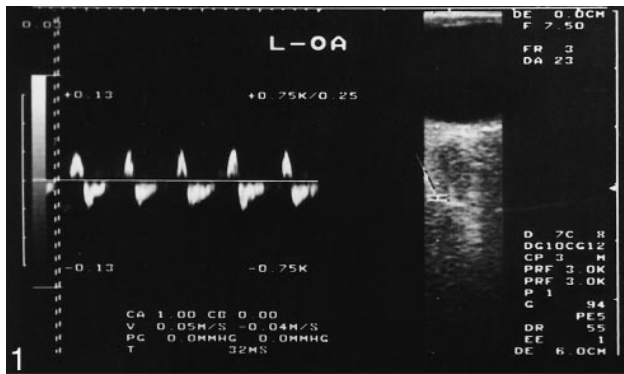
Doppler spectrum of the left ophthalmic artery shows end-diastolic flow reversal. Resistive index is 1.80.
